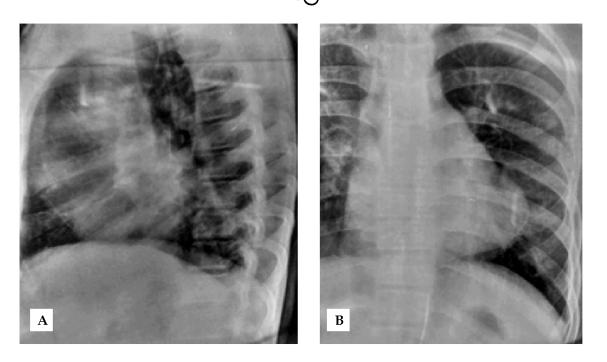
A,B: X-RAY chest lateral and PA view depicting pericardial calcification(white bold arrows).
